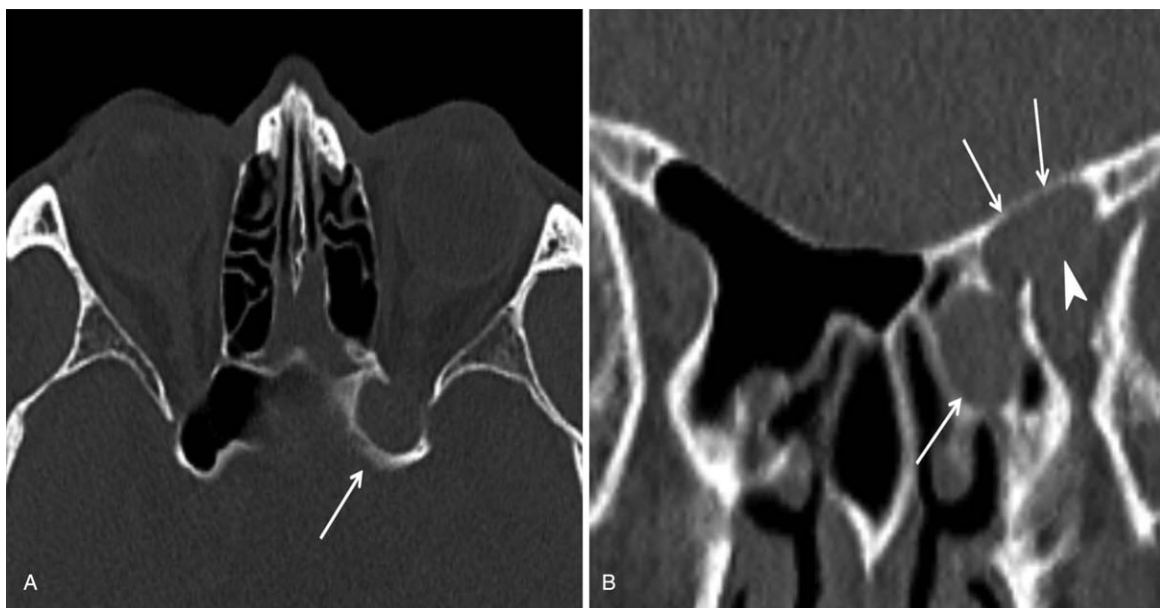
Ostiomeatal complex CT of the same patient. Axial (A) and coronal (B) scans showed an expansile soft tissue density completely filling the left Onodi cell (A and B, arrows). The lesion accompanied bony remodeling at the inferior wall of the left Onodi cell (B, arrowhead).
